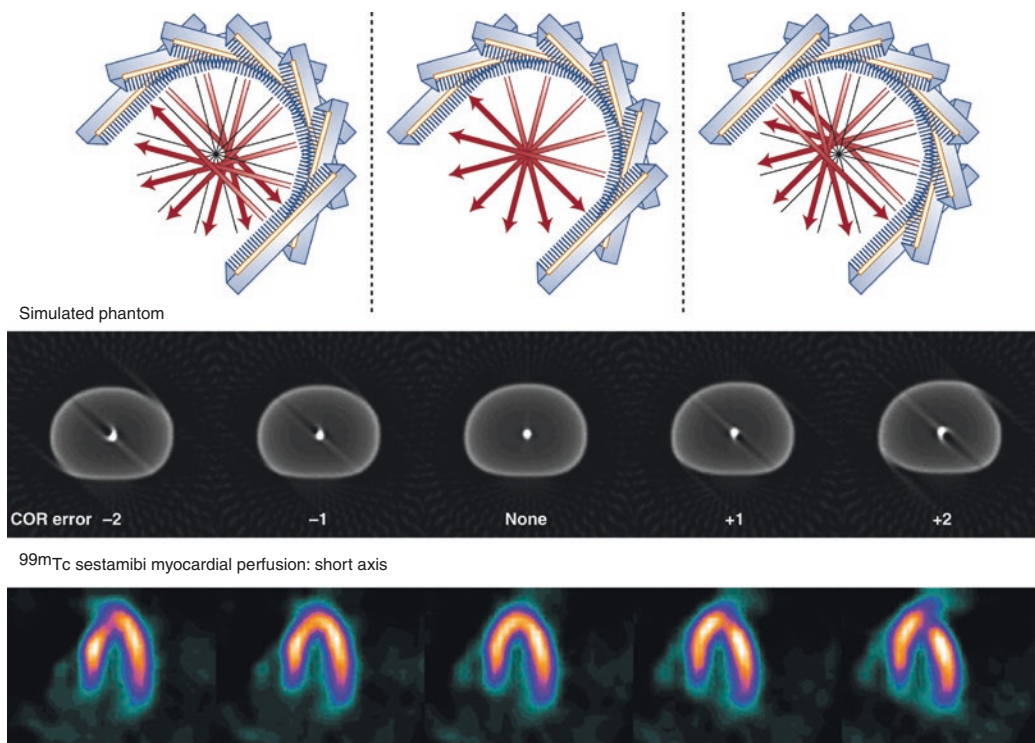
Center of rotation (COR). COR is a calibration performed frequently to ensure that the frame of reference used by the computer in reconstructing images is aligned with the mechanical axis of rotation of the SPECT camera system. If the center of rotation is properly calibrated, a radioactive point source placed in the center of the camera orbit should project to the center of the computer matrix. These results are seen in the *middle panels*
